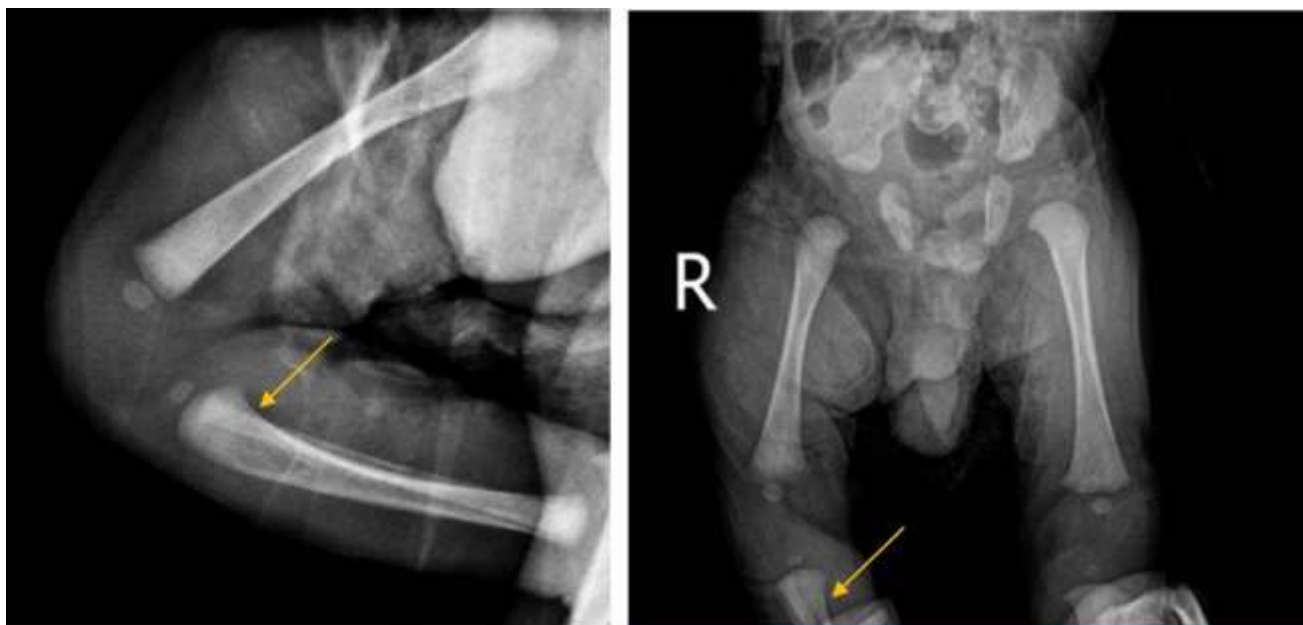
X-ray radiographic image of the proximal tibia
